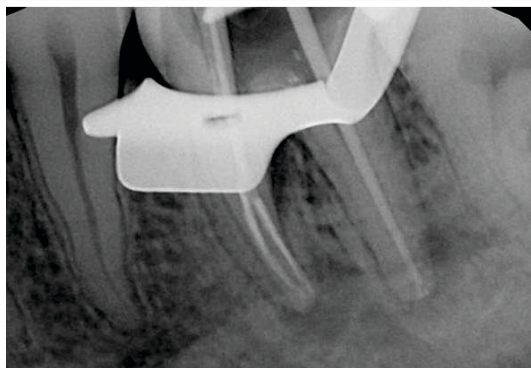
Master cone radiograph after bypassing the fractured instruments
